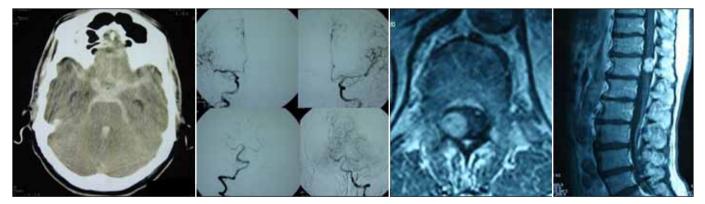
Initial CT scan of a patient showed diffuse subarachnoid hemorrhage (above left). Initial DSA revealed no abnormalities both in anterior and posterior circulation injections (above middle). Spinal MRI investigations in one patient revealed a 2.2x1.2x1 cm-sized mass-lesion located intradural extramedullary at Th 12 level, which was found to be responsible of SAH (above right).
